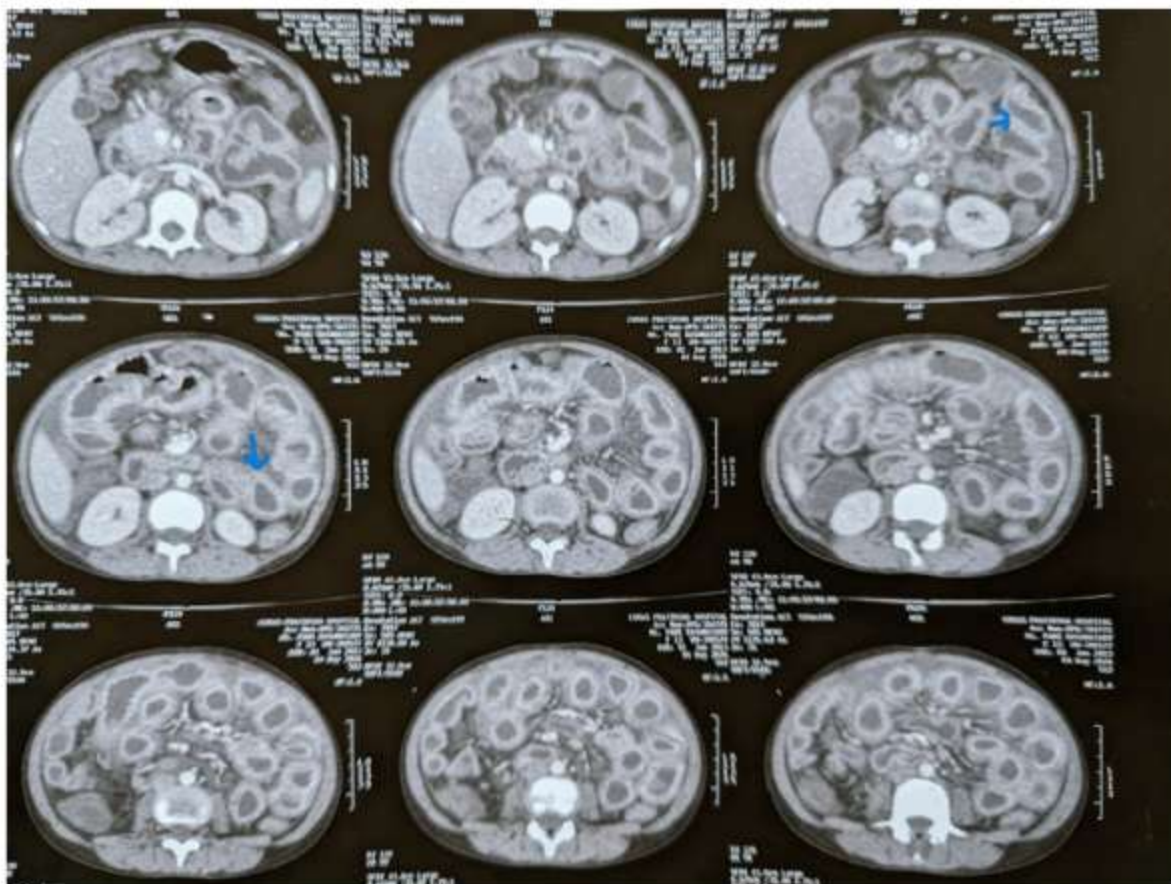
target sign as seen on CT abdomen
